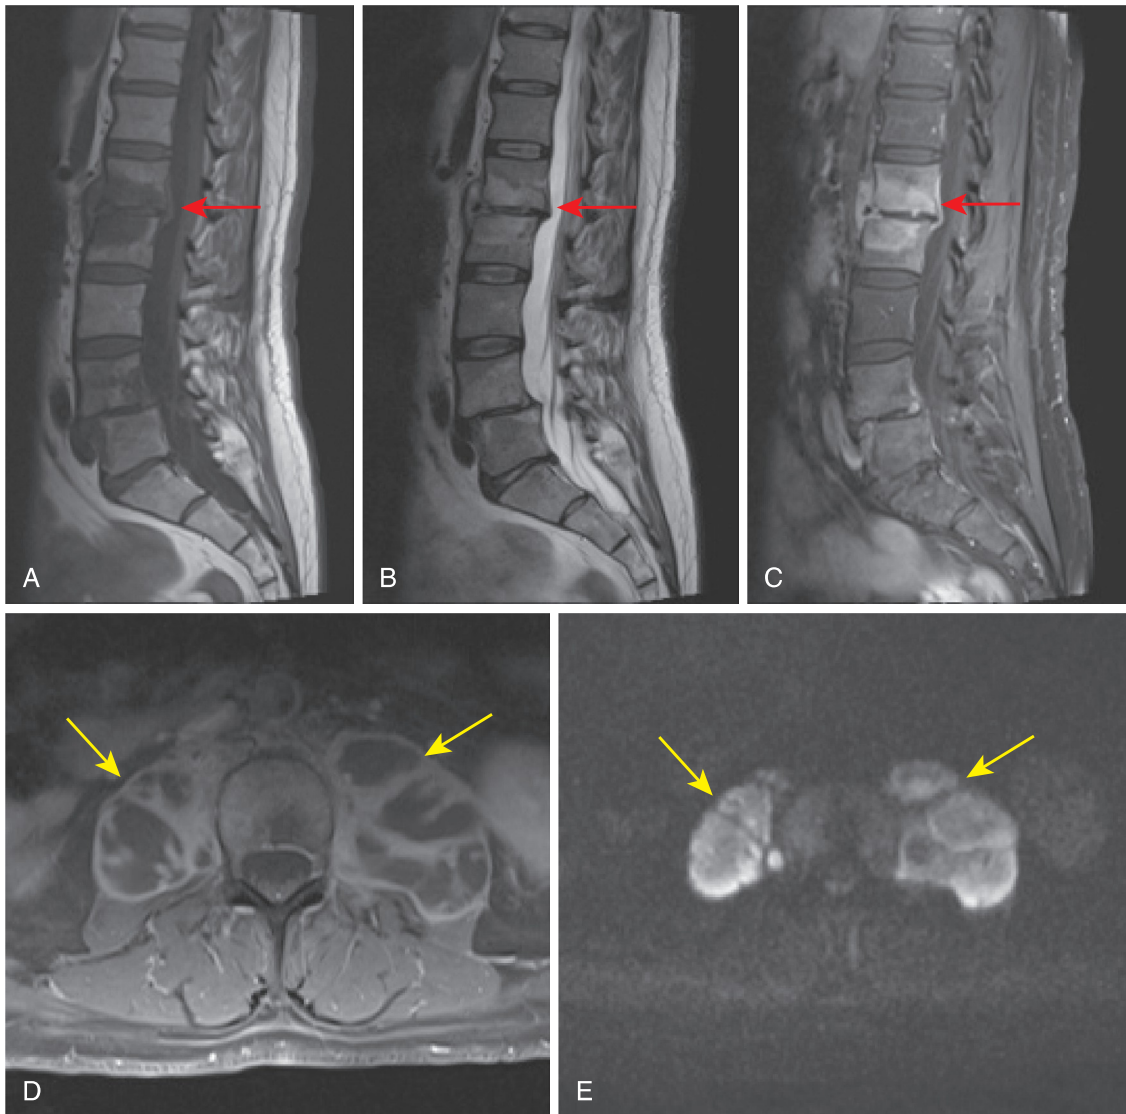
A 62-year-old recent immigrant from Mexico. Sagittal T1 (A), T2 (B), and fat-saturated postcontrast T1 (C) images show abnormal vertebral body marrow signal abnormality at L1-L2 (red arrows). There is a small epidural phlegmon and prespinal soft tissue enhancement at L1-L2. Axial postcontrast (D) and DWI (E) images show large, rim-enhancing fluid collections with diffusion restriction in both psoas muscles consistent with large abscesses (yellow arrows). Sampling of this fluid revealed *Brucella* as the causative organism.
